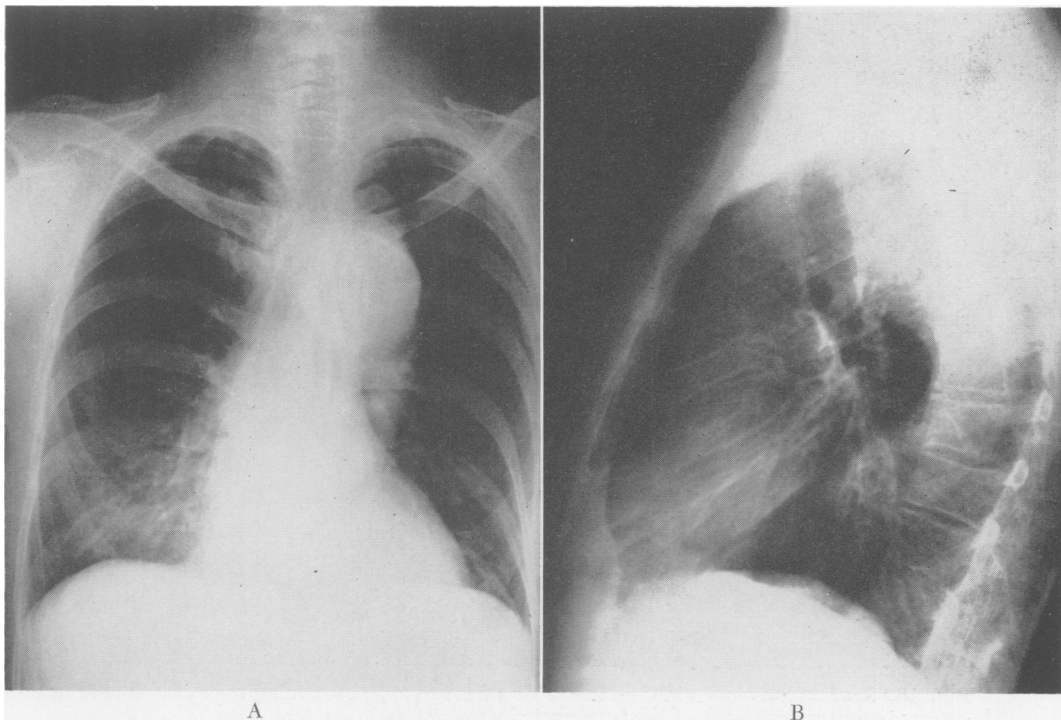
A and B. Roentgenograms of chest in Case 2, in postero-anterior and lateral projections, showing a fusiform aneurysm involving the distal arch and descending thoracic aorta.
